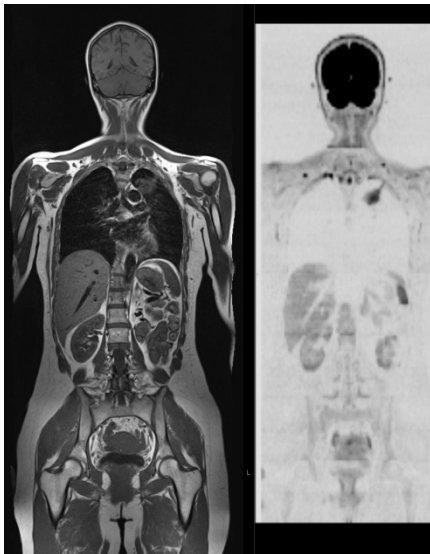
Stage 1 Lung Cancer. DWI sequence conspicuity is not affected by breathing, or pulsation
